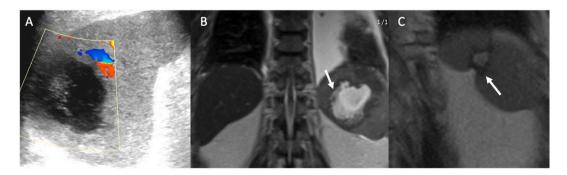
Splenic tuberculosis. A) US of spleen demonstrates a heterogenous hypoechoic structure $(4.9 \text{ cm} \times 4.3 \text{ cm})$ without internal vascularity, suggestive of an abscess. B) T2-weighted image shows a hyperintense lobulated mass (arrow), suggestive of an abscess. Left pleural effusion is also identified. C) MRI 7 months post anti-TB treatment reveals near complete resolution of the splenic lesion with a small residual and scarring (arrow).
